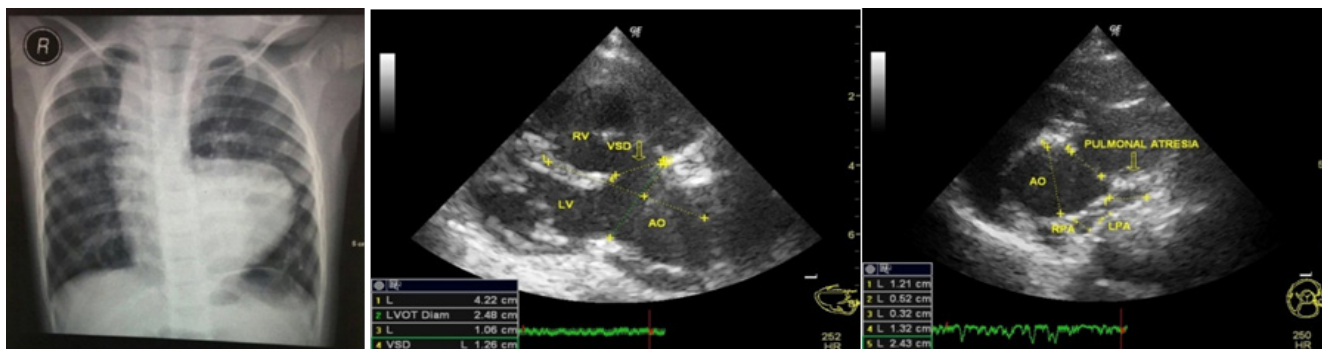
Chest X-Ray and Trans Thoracic Echocardiography (TTE)
